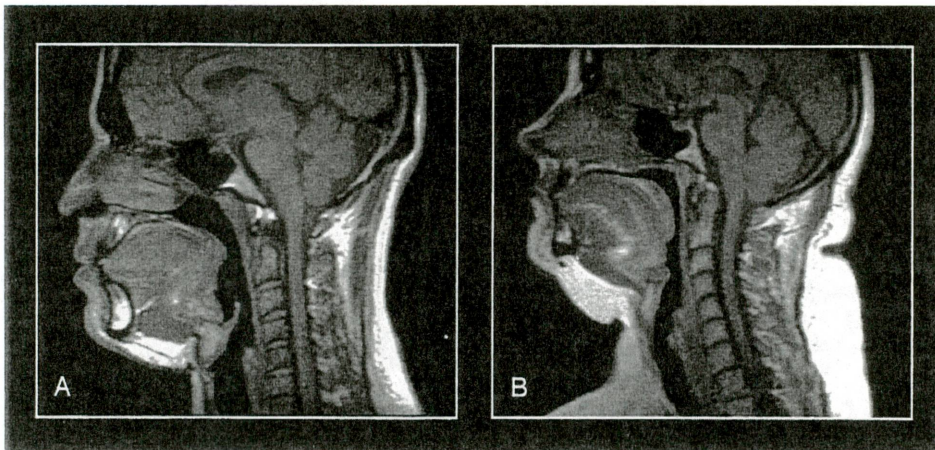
A. MRI of normal airway. B. Airway of patient with sleep apnea. (Adapted from [Schwab, 1998]).
